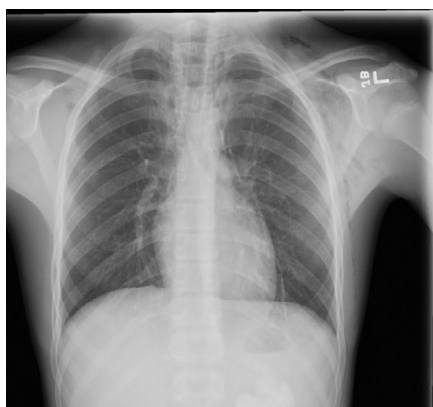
Pneumomediastinum resolving on chest x-ray.
